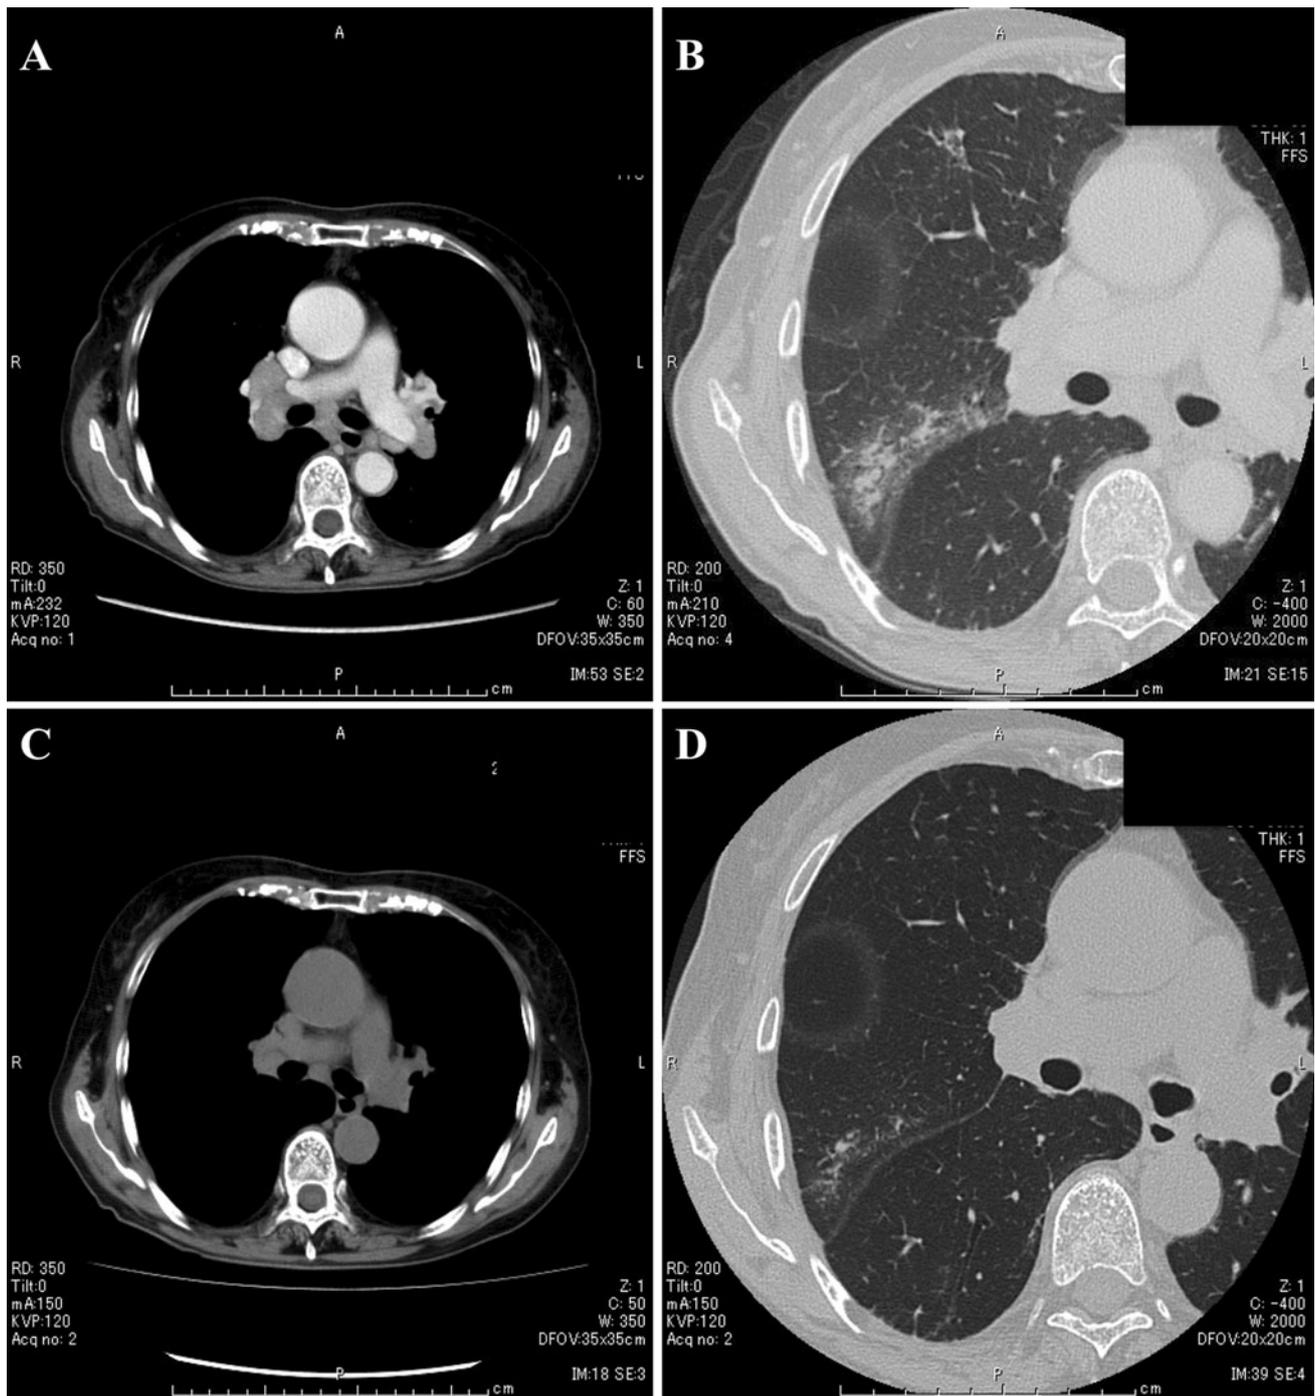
Computed tomography scan on admission (a, b) and 1 year after admission (c, d). a Bilateral hilar lymphadenopathy is evident, b small trabecular shadows with ground-glass opacities in the right
